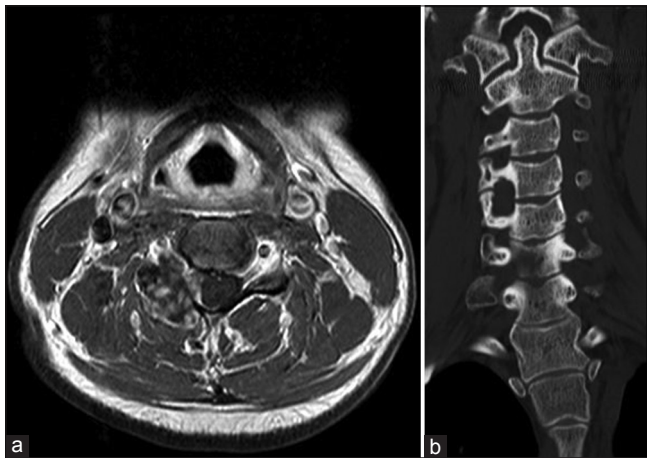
(a) Preoperative axial magnetic resonance imaging shows the lobulated marginated heterogeneous enhancing lesion measuring approximately 15 mm × 23 mm in the right lamina of C4, right epidural space, and neural foramen of C4-5. (b) Coronal computed tomography shows widening of the right neural foramen at C4-5
